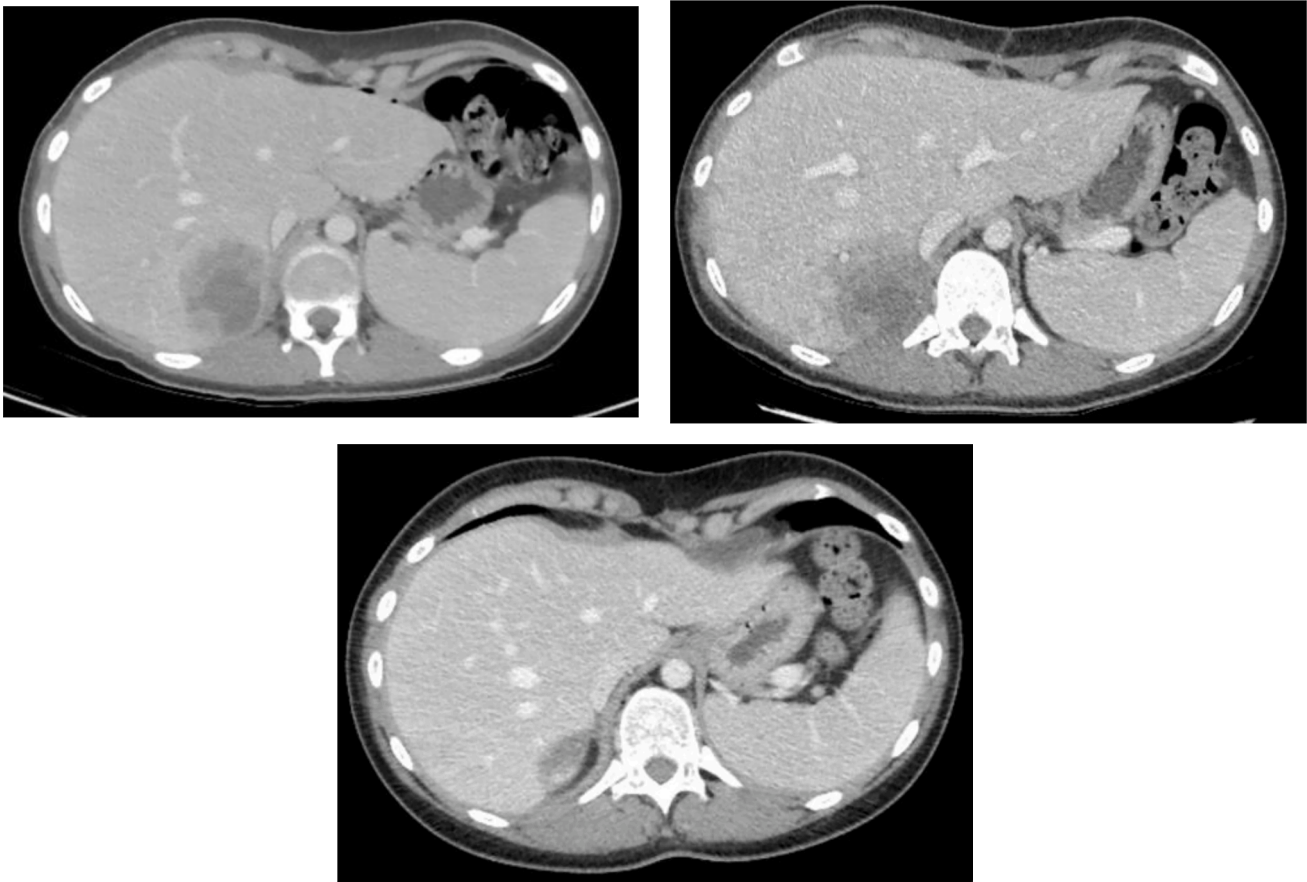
Computed tomography of the residual hepatic mass during treatment. (a) Post-operative site of residual disease. (b) Early CT three weeks after start of pembrolizumab. (c) CT one month after the conclusion of chemotherapy regimen.
